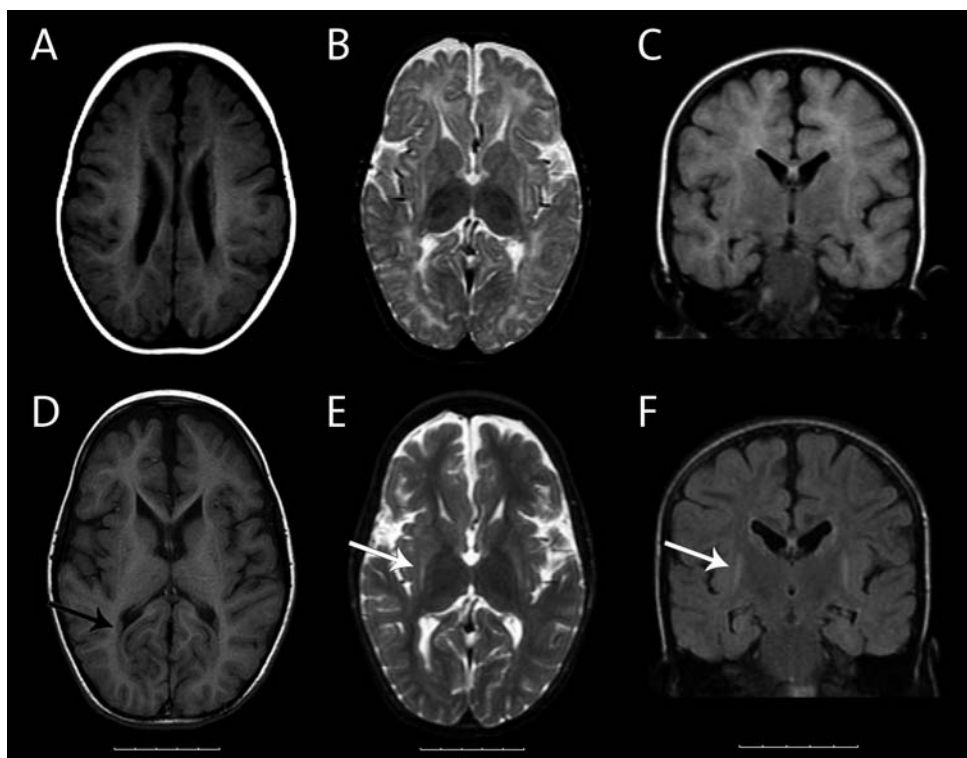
Brain MRI made at the age of 13 months (images A, B, and C) and at the age of 4 years and 10 months (images D, E, and F). A and D T1-weighted images showing bilateral periventricular nodular heterotopia with the intensity of gray matter (black arrow in image D). B and E T2-weighted images showing hyperintensity of the putamen and atrophy of the putamen and globus pallidus (white arrow in image E). C and F Flair images, coronal view, showing bilateral hyperintensity of the putamen, more clearly visible on image F made at a later age (white arrow), and mild atrophy of the hippocampi.
